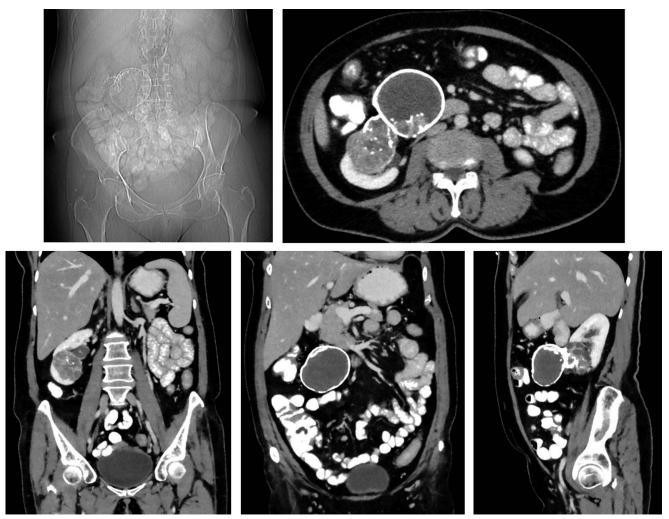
Abdominal X-ray and computed tomography of the abdomen and pelvis showing a large heterogenous mass of the right kidney with cystic, solid, and calcified components with a large calcified cyst wall.
